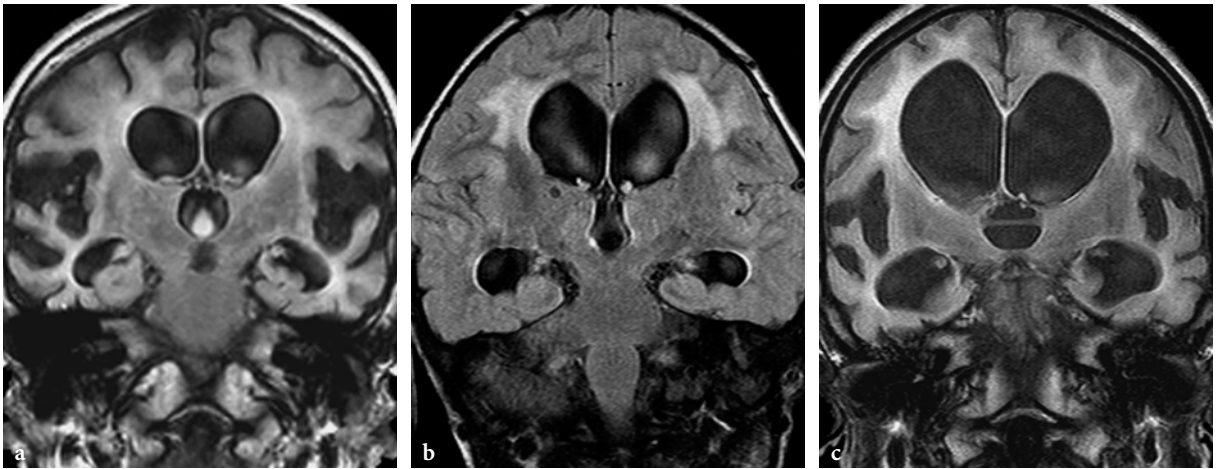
White matter signal abnormalities in various forms of mucopolysaccharidosis on coronal FLAIR images. a 8-year-old female with Sanfilippo disease. Prominent enlargement of the extra- and intracerebral CSF spaces is conspicuous in conjunction with ill-defined, predominantly periventricular white matter signal abnormalities. b 6-year-old female patient with Maroteaux-Lamy disease. Ventricular enlargement without brain atrophy. The white matter lesions spare the subcortical U-fibers. c 10-year-old male patient with Hunter disease. Similar findings as in Figure 13.83a
